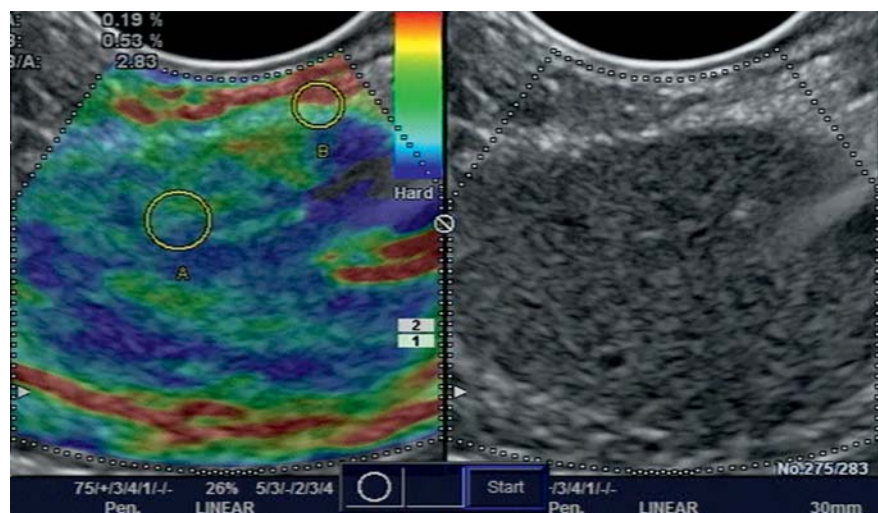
Endoscopic ultrasound elastography showing inhomogeneous hardness (blue = significant hardness; green = intermediate hardness).
